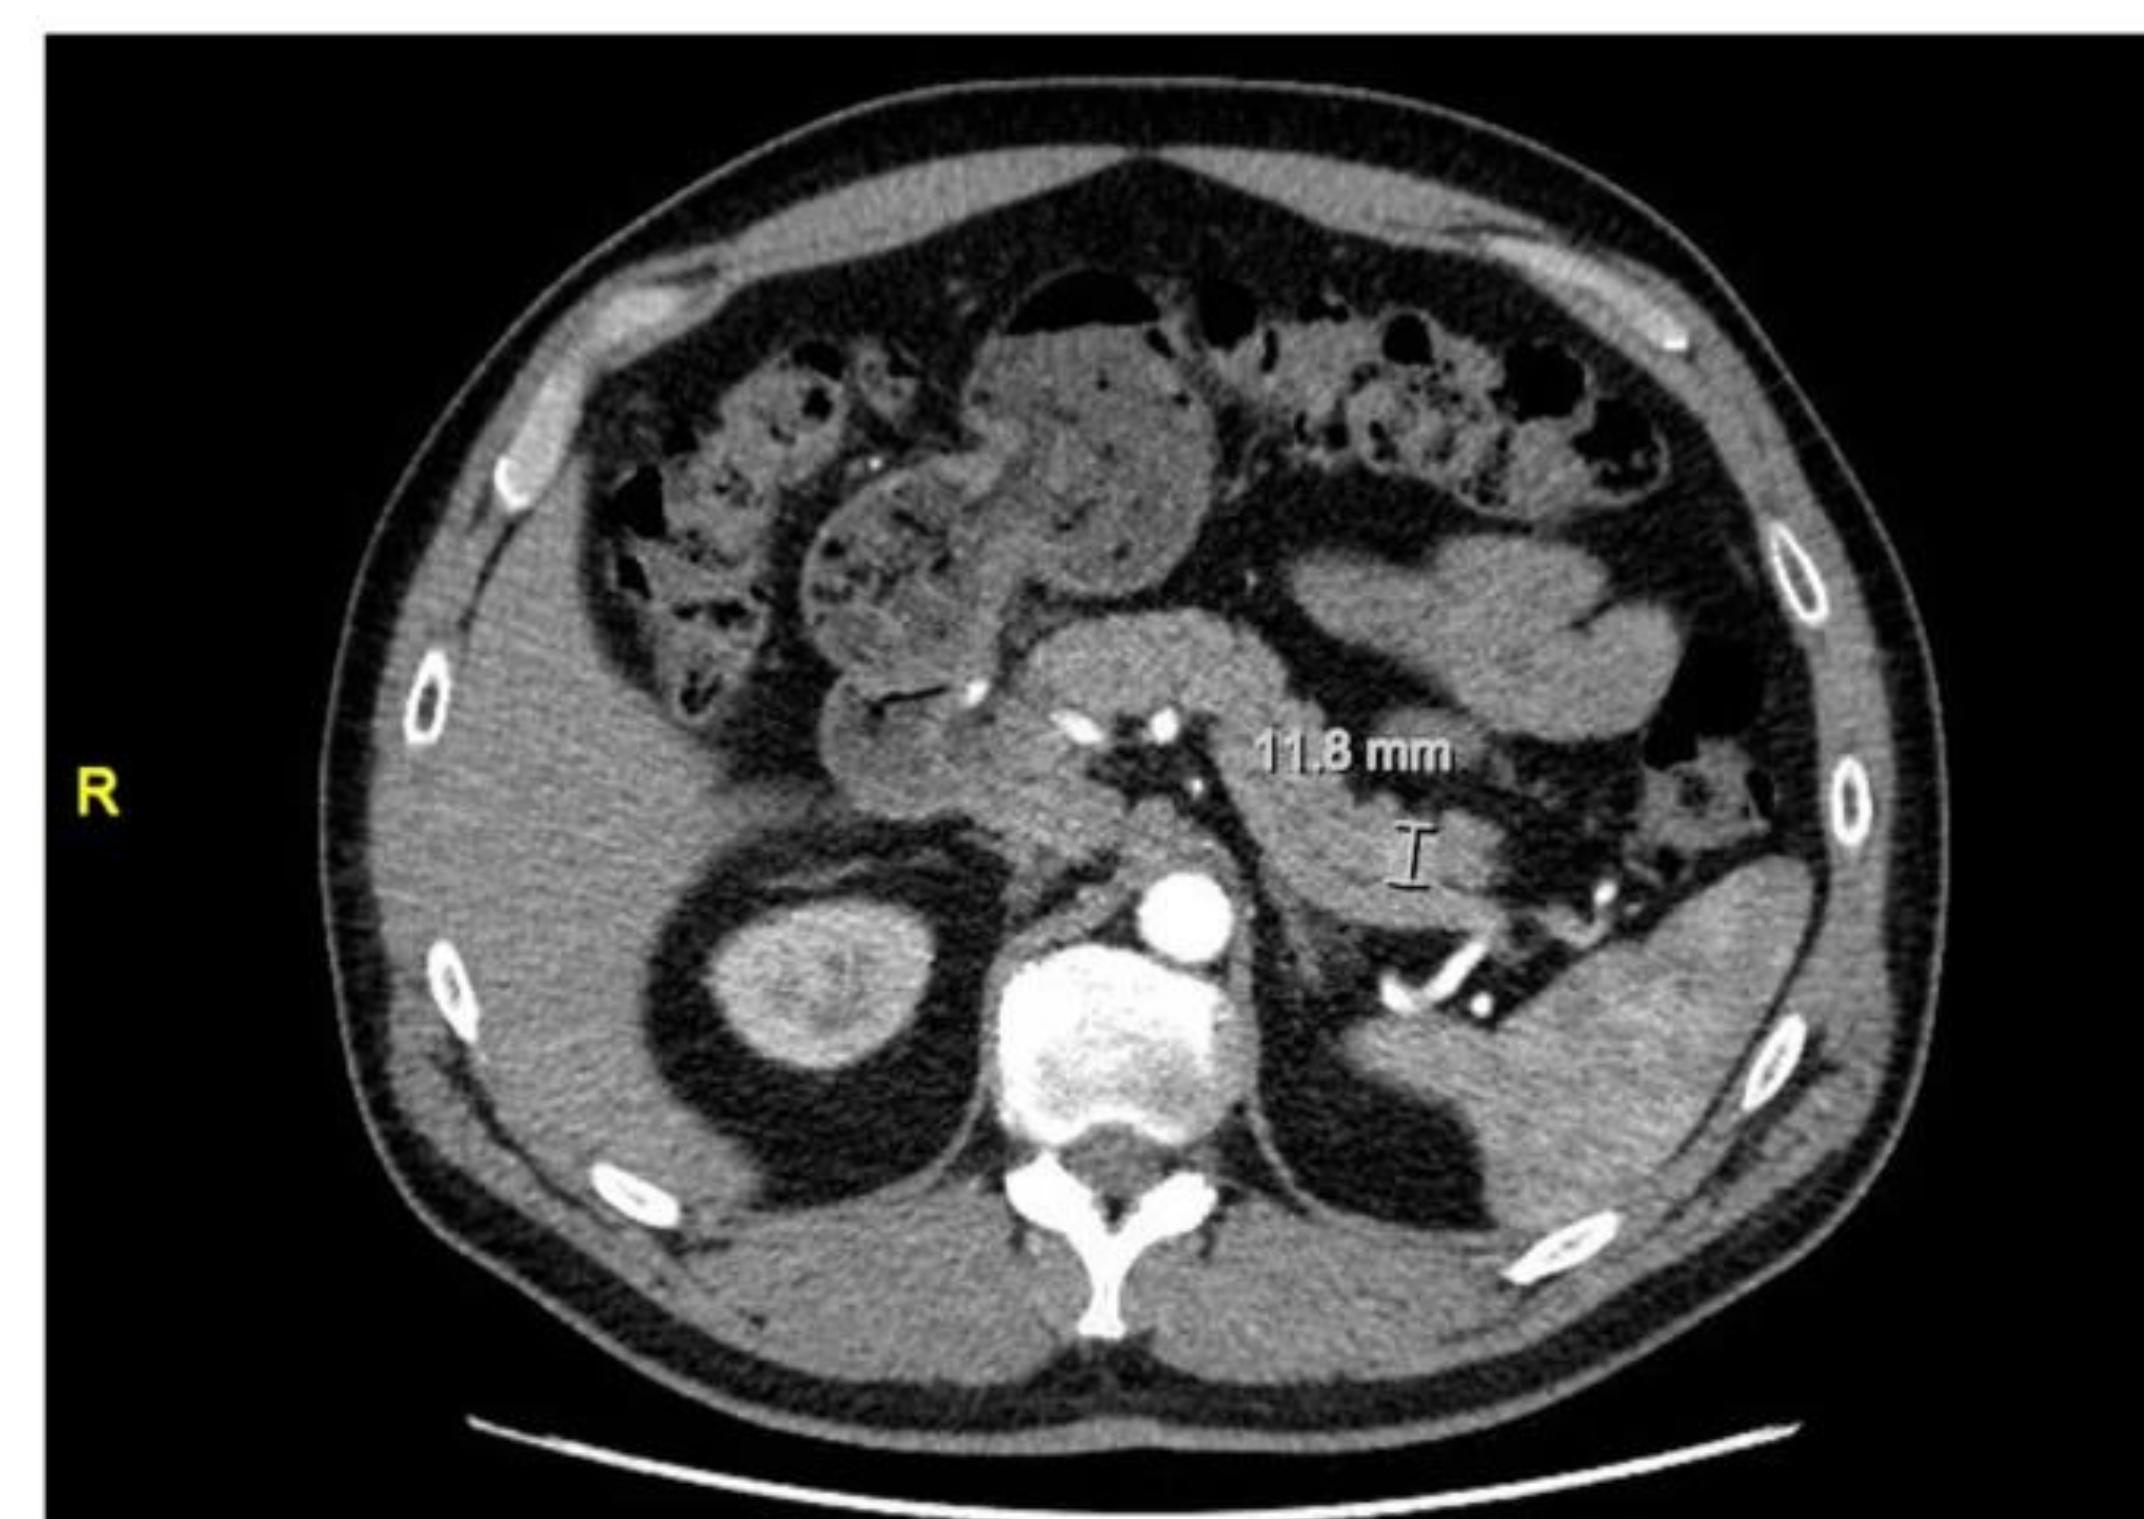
Axial computed tomography of the abdomen. Image demonstrating hyperdense mass lesion at the pancreatic tail (mark).
